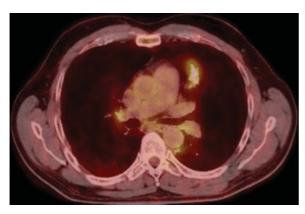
Corresponding PET/CT image of Fig. 1.
